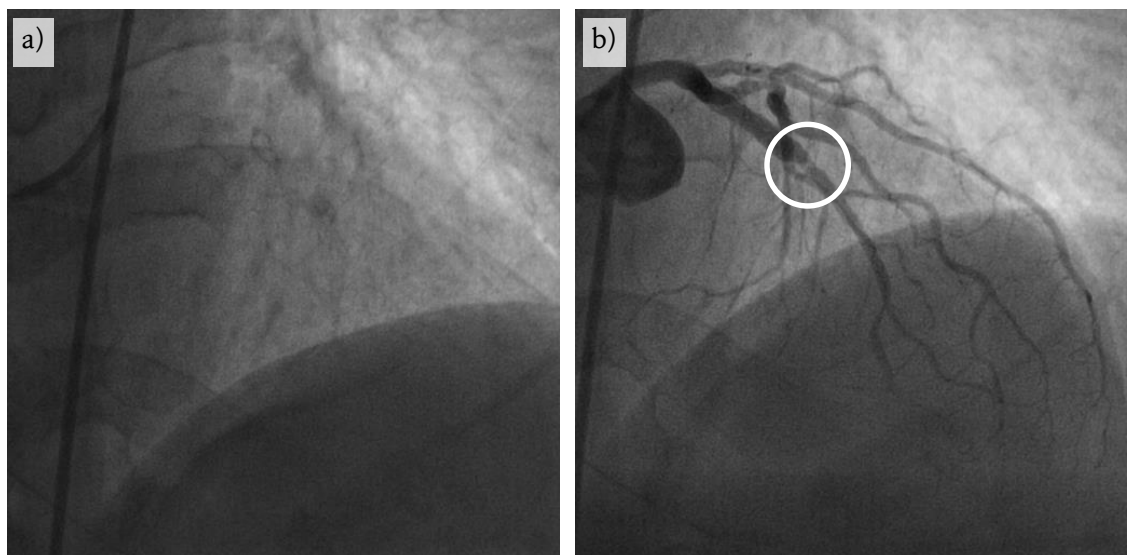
a) X-ray fluoroscopic image of the heart from PA view. Poor soft-tissue contrast of the heart is evident, showing only the upper cardiac border of the heart. b) Injection of a radio-opaque contrast agent into the bloodstream reveals a complex coronary vessel structure and helps reveal the location of the stenosis in the X-ray image (*circled in white*).
